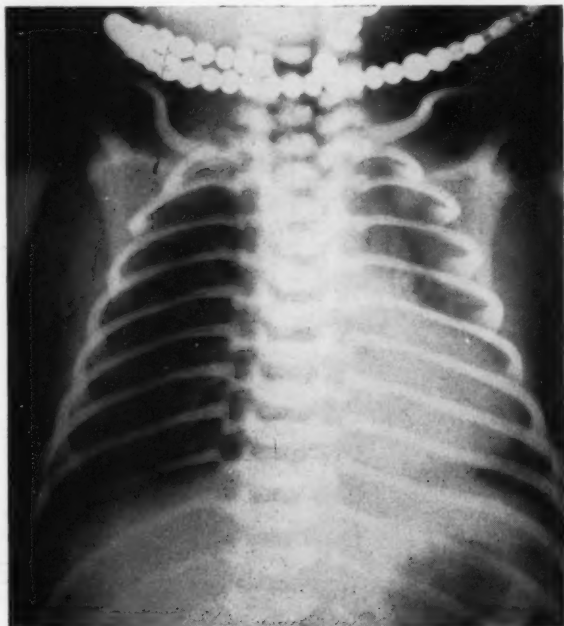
X-rays showing massive atelectasis of the left lung with shift of the central shadows.
